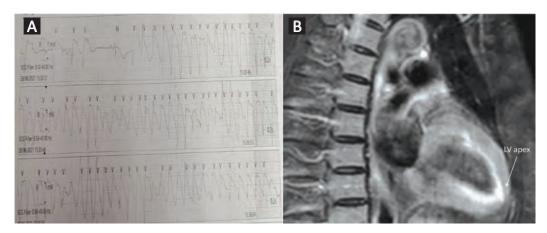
(A) Telemetry revealing significant torsades de pointes. (B) Cardiac magnetic resonance imaging showing oedema, which is worst in the apical region.
